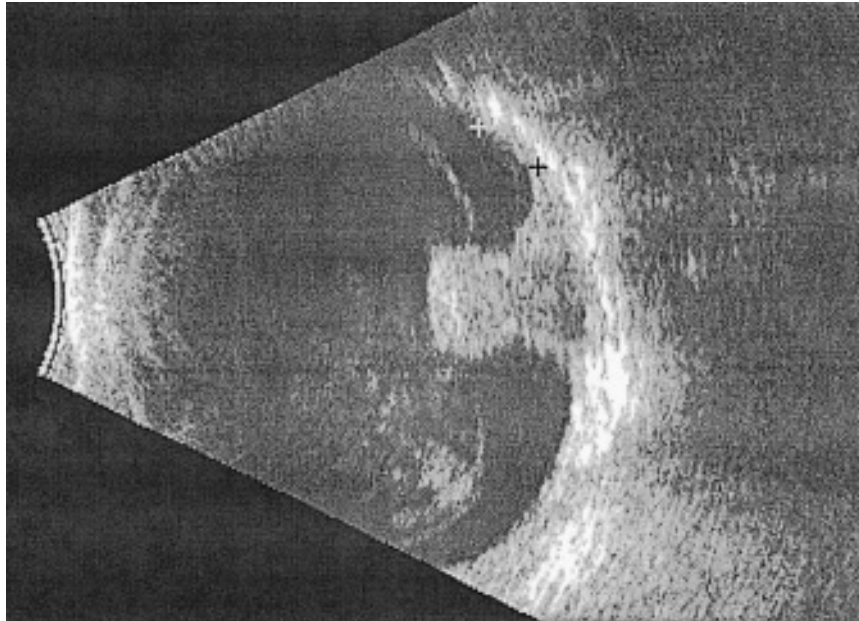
Intraoperative ultrasonography confirms that the I-125 plaque extends 3 mm beyond the border of the melanoma at 90° intervals around the circumference. Cursors identify tumor border and plaque edge. 85-year-old man with collar-button shape melanoma measuring 10 mm x 10 mm x 6.3 mm.
